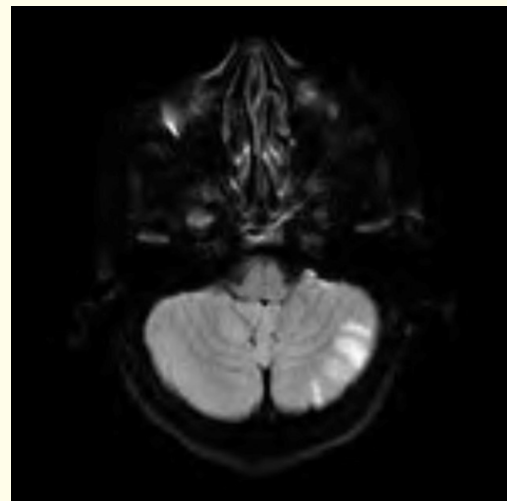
DWI noted Left Cerebellar infarct.
